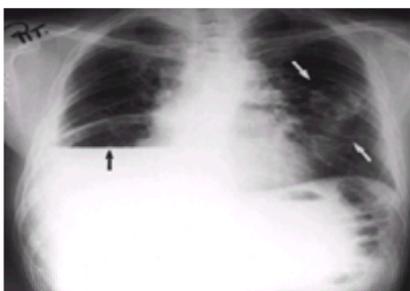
A postoperative chest radiograph demonstrates an air-fluid level (*black arrow*) in the right pleural space following an open lung biopsy. In the left lung, two cavitary masses (*white arrows*) are identified. The masses, which waxed and waned during a period of months, were pathologically proved to be Wegner's granulomatosis.
